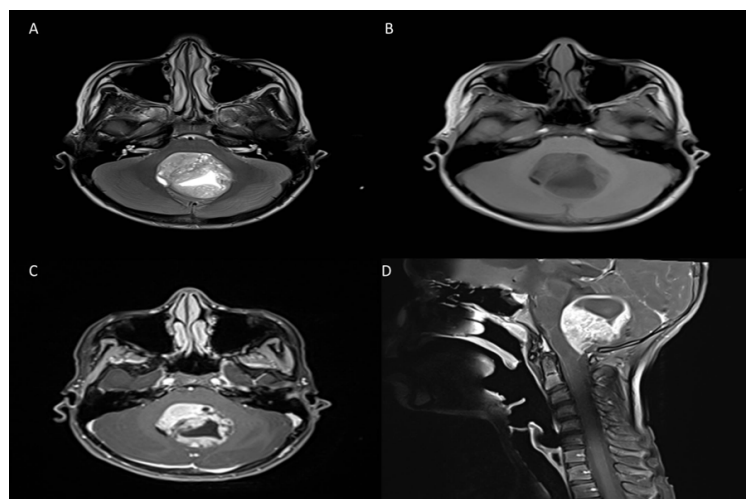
Initial MRI examination.
